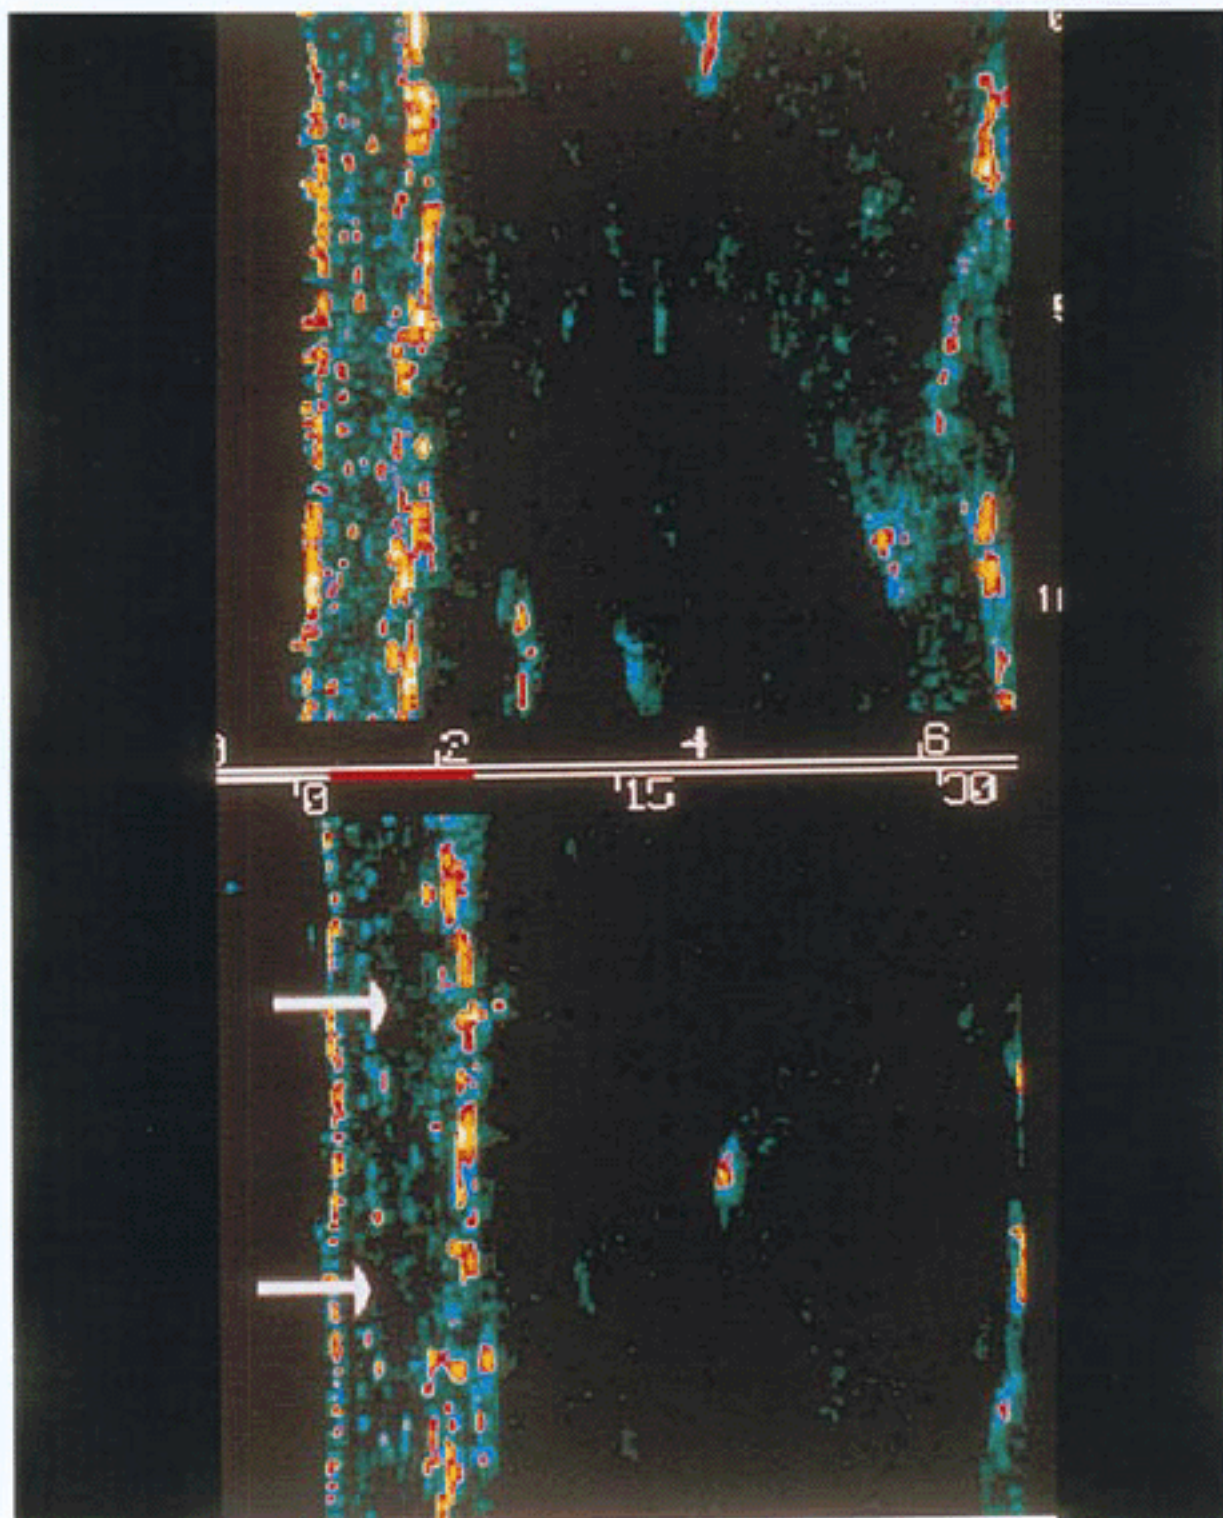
Ultrasound images of normal skin upper arm (upper image) and PWS upper arm (lower image) (see arrows). (For explanation of colour code see text).
